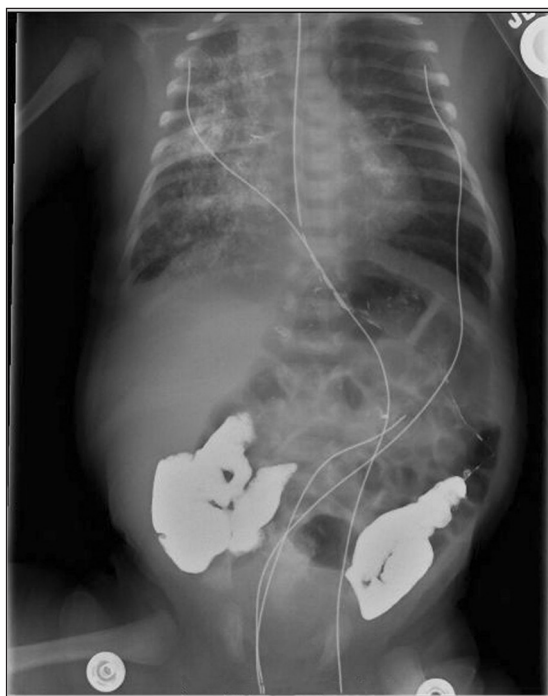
Chest and abdominal radiograph showing bilateral parenchymal haziness (right greater than left side), large stomach bowel and areas of mildly distended bowel loops.
